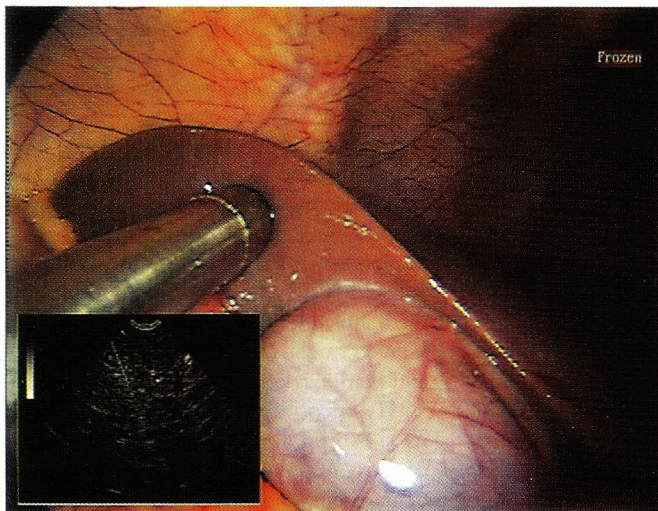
Assessment of the liver parenchyma by direct contact ultrasound.
